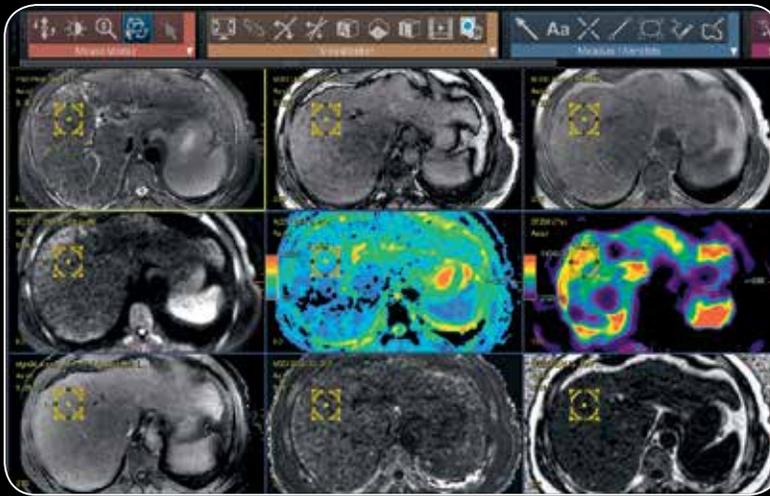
Example of a multi-parametric layout for a patient with alcoholic cirrhosis. Top row viewports: T2 PROP/FSE, In-Phase, Out-of-Phase. Middle row: DWI, ADC map, stiffness map. Bottom row: Dynamic LAVA, R2* map, Fat Fraction. Notice the high stiffness value (9.6 kPa) related to the high fibrosis stage, the mild Fat Fraction increase (10.3%), the normal range ADC value (1508.10-6 mm²/s), and R2* value (64.8 Hz).
